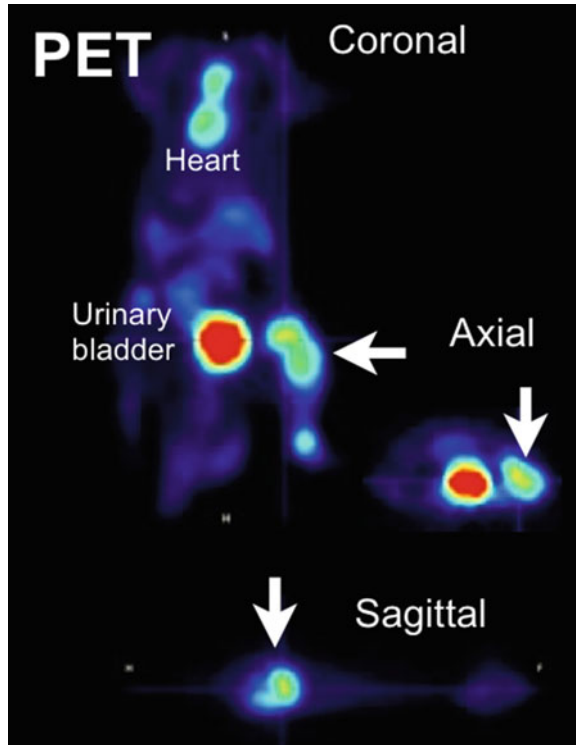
^{18}F -FDG PET images in coronal (*left panel*), axial (*right upper panel*), and sagittal orientation (*lower panel*) of a bone metastasis. Besides FDG uptake in the bone metastasis, there is physiological accumulation in the heart and urinary bladder by blood and urine, respectively. *Arrows* point at bone metastasis
